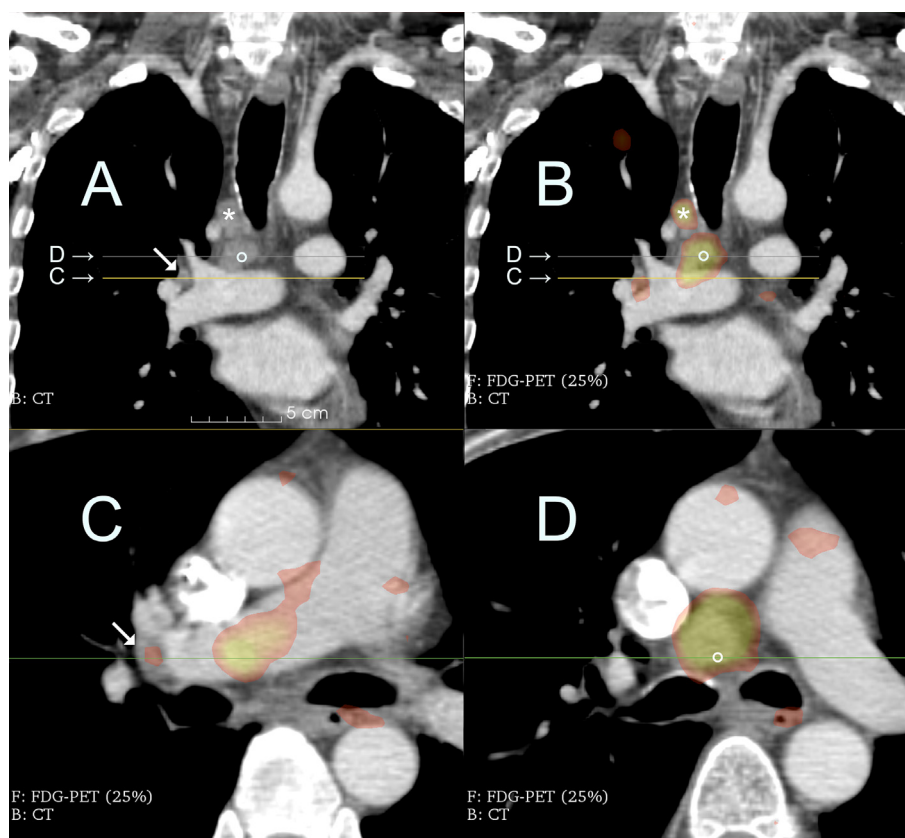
Delineation exercise case. The exercise case was a patient with a squamous cell carcinoma of the right upper lobe. Regarding the regional workup, the chest CT-scan described a 1.1×1.7 cm node in upper 4R nodal station (* in frames A and B) and contiguous nodes up to 2×2.4 cm in lower 4R station (pre-carinal) (° in frames A–C) and a node in station 10R with a 9 mm short axis (white arrow in frames A and C). The PET/CT report described lymph nodes with SUVmax of 12.2 and 13 in upper (*) and lower 4R (°), respectively. Note a longitudinal stretch of the PET signal possibly due to breathing motion, best seen on the pulmonary artery on frame B and C. The results of the EBUS procedure confirmed the infiltration of the upper 4R node, while the analysis of the lower 4R puncture revealed fatty tissue without neoplastic cell. Abbreviations: EBUS = Endobronchial Ultrasound, CT = Computed Tomography, FDG = Fluorodeoxyglucose, PET = Positron Emission Tomography, SUVmax = Maximum Standard Uptake Value.
